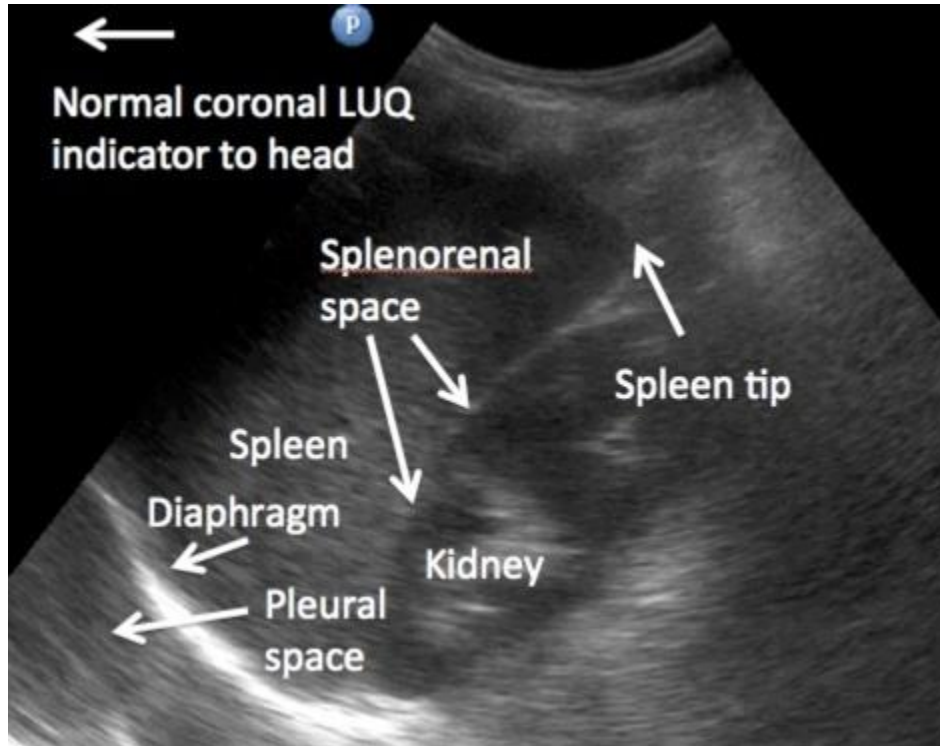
shows ultrasound image of spleen(Blessmann-2003)
